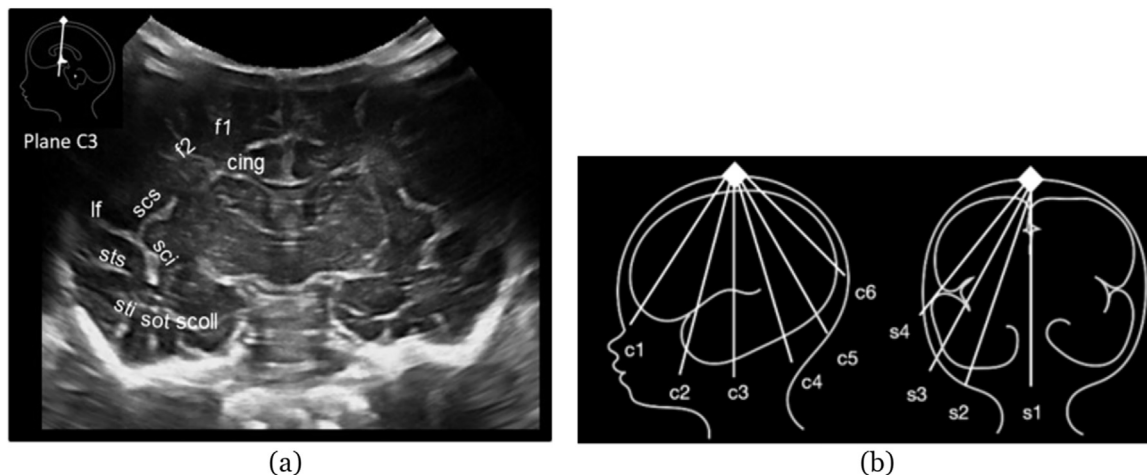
(a) C3 cranial ultrasound plane of a pre-term infant showing the main principal sulci. f1, superior frontal sulcus; f2, inferior frontal sulcus; cing, cingulate sulcus; lf, lateral or Sylvian fissure; scs, sulcus circularis superior; sci, sulcus circularis inferior; sts, superior temporal sulcus; sti, inferior temporal sulcus; sot, sulcus occipitotemporalis; scoll, sulcus collateralis. (b) Anatomic references for each plane: c1, orbital border; c2, sphenoidal ridge; c3, foramina of Monro and third ventricle; c4, fourth ventricle; c5, choroid plexus; c6, visibility of parieto-occipital sulcus in the inferior tier of the image; s1, midsagittal; s2, lateral ventricles; s3, lateral fissure; s4, lateral fissure at the bottom of the image.
